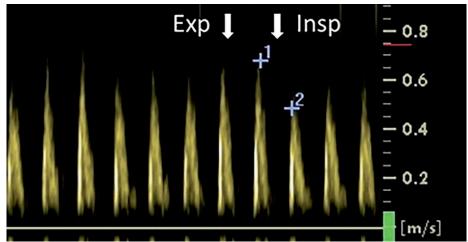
A decrease of > 25% in the peak E-wave velocity (as determined by a pulsed-wave Doppler recording at the level of the mitral leaflet tips in an apical four-chamber view) on the first beat after inspiration. Exp: expiration, Insp: inspiration
